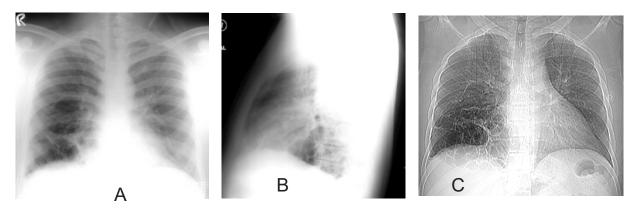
A frontal (a) and lateral (c) chest radiographs along with scanogram (c) showing thin walled multicystic changes in the right lower lobe (blue and white arrows) without any obvious air-fluid levels. Note that right upper as well as left hemithoraces are unremarkable for any obvious pathology.
